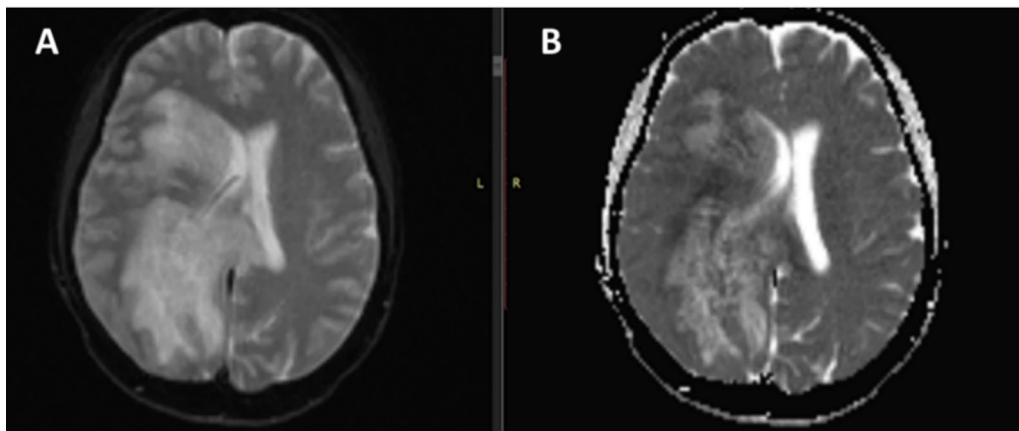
Axial A DWI and B ADC MR images of the brain. It shows restricted diffusion of the white matter edema on both DWI and ADC MR mapping
